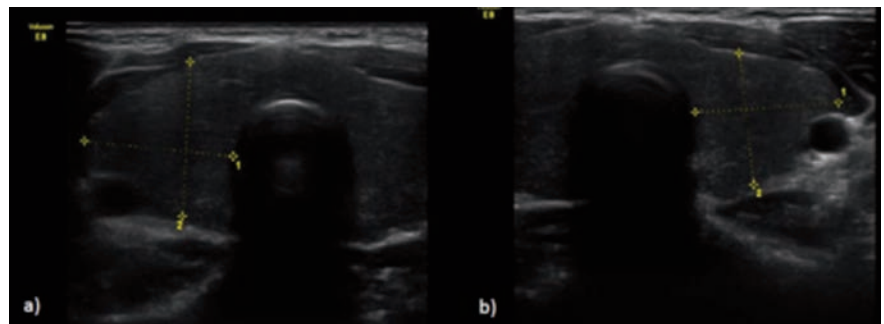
Thyroid ultrasound (24/10/2017): thyroid with globally hypoechoic texture, with no solid nodules; no increase in vascularization; no latero-cervical adenopathies. a) Thyroid right lobe; b) Thyroid left lobe.
